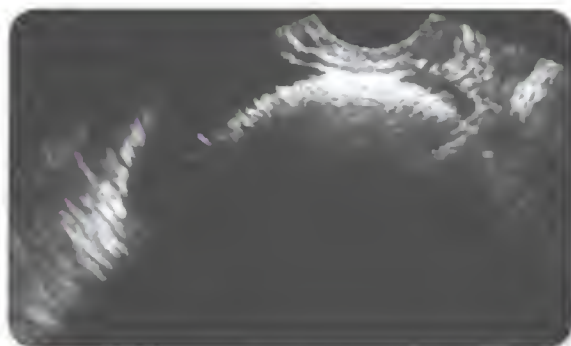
'Tip of iceberg' sign on ultrasound is seen in dermoid cyst of ovary; a highly echogenic mass with posterior shadowing is noted; the echogenic area hides the structures posterior to it
